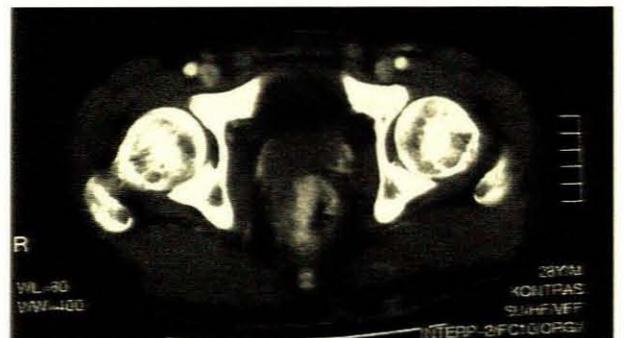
KS: CT scan image of rectal mass.
